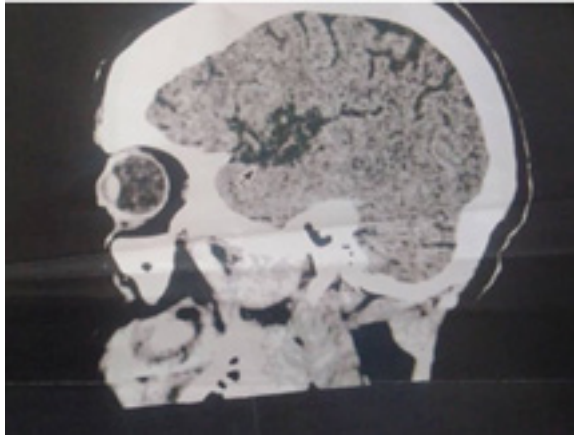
CT scan brain showing an enlarged frontal bone
